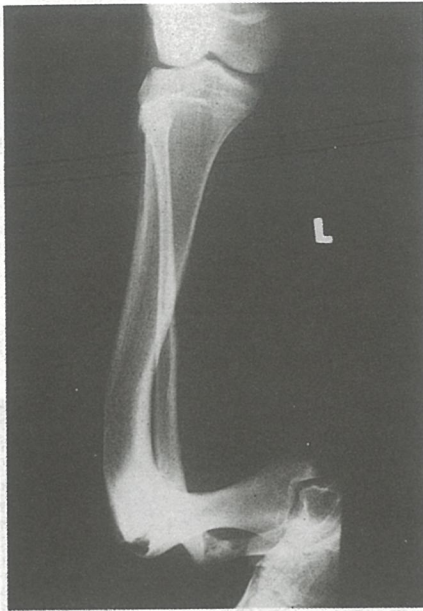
A The radiograph showing congenital pseudarthrosis of the tibia type IV
